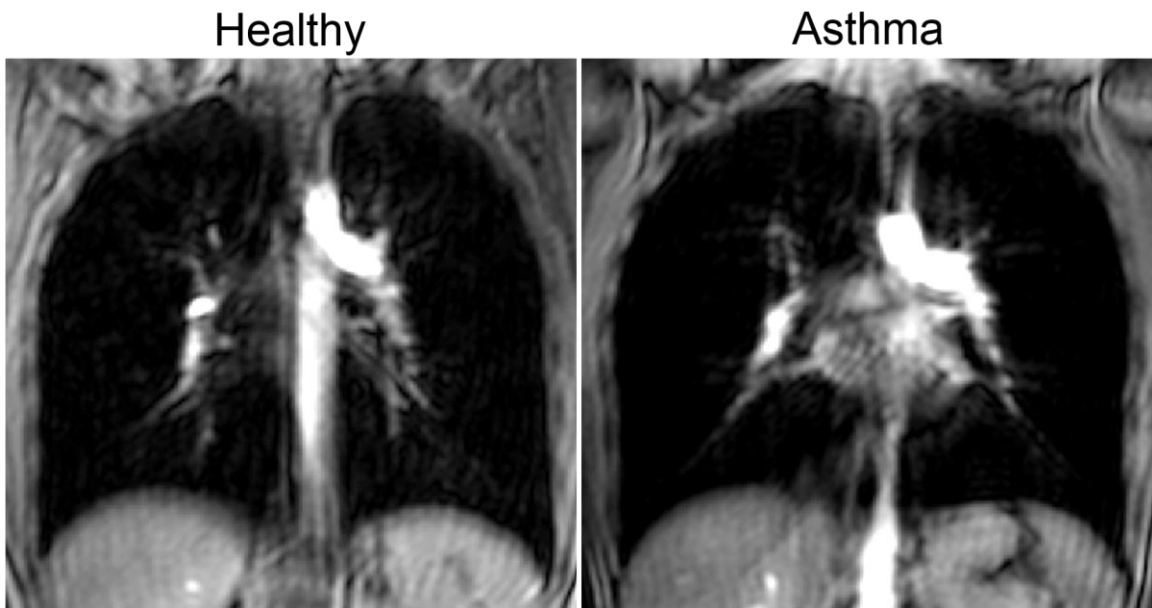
Representative coronal conventional ^1H MRI of a healthy volunteer and an asthmatic subject.
